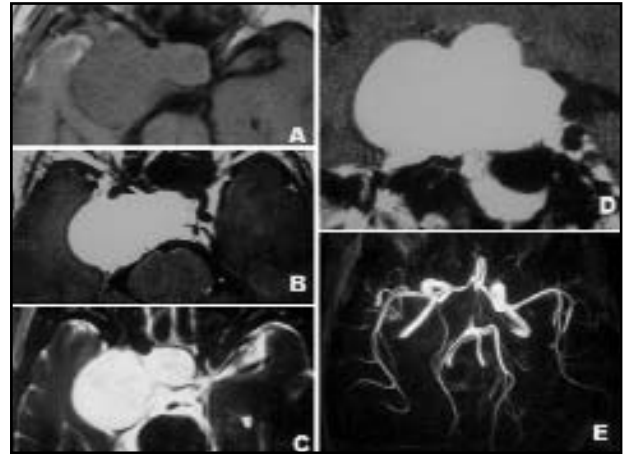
Patient 2. Right para-sellar and supra-sellar lesion iso/hypointense in T1-weighted image (1A), brightly enhancing after gadolinium infusion (1B and 1D) and hyperintense in T2-weighted image (1C). MRA (1E) shows displaced right-sided vessels of the circle of Willis, which have preserved flow. Right internal carotid artery is seen within lesion.
